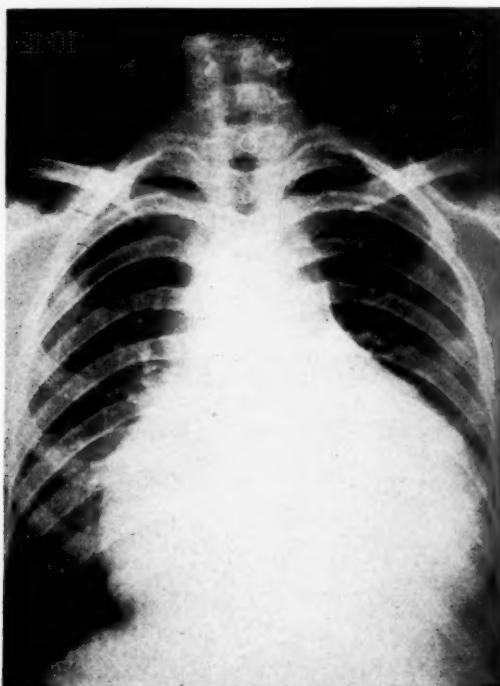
Case 10, October 12, 1933. Roentgenograph of the chest, showing massive tuberculous pericardial effusion before paracentesis. Necropsy later confirmed the diagnosis.
